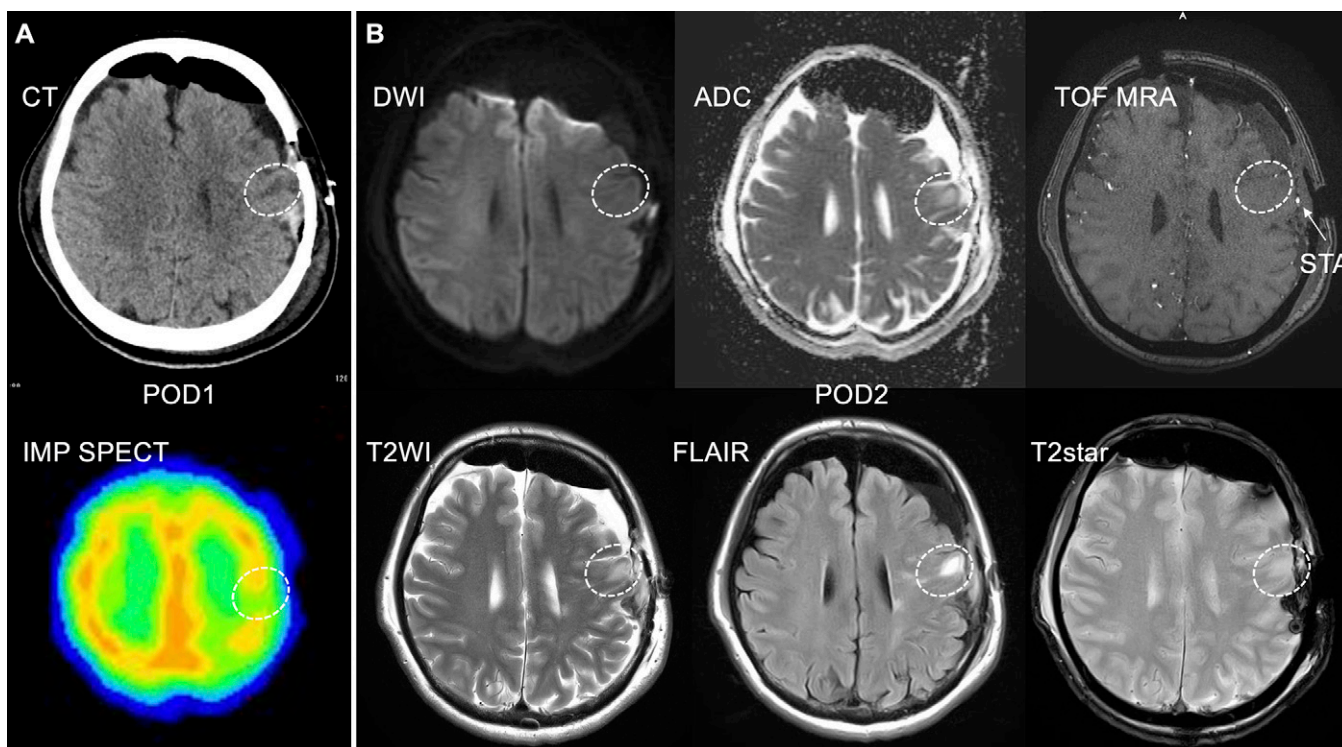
A: Non-contrast-enhanced computed tomography (CT) (upper) obtained on POD 1, showing a low-density parenchymal change in the frontal subcortical white matter at the site of the STA-MCA anastomosis. ^{123}I -IMP SPECT (lower) showed relatively decreased cerebral blood flow at the site of the low-density lesion (dashed circle). B: POD 2 MR images of the corresponding slice of the CT and ^{123}I -IMP SPECT revealed increased intensity on apparent diffusion coefficient (ADC), T2-weighted (T2WI), fluid-attenuated inversion recovery (FLAIR), and T2*-weighted (T2star) images at the site of the STA-MCA anastomosis, although no apparent changes were observed on the diffusion-weighted image (DWI) or time-of-flight MR angiography source image (TOF MRA). These postoperative radiological findings where intraoperative extravasation of the ICG dye had been observed suggested local vasogenic edema without cerebral hyperperfusion after STA-MCA anastomosis.
